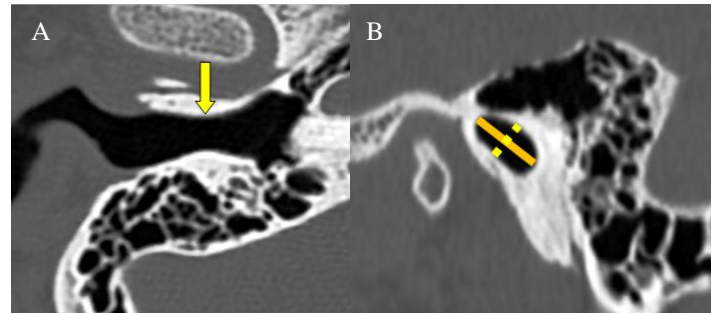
Axial CT image of temporal bone. 2nd measurement point is at the level of isthmus (yellow arrow), 2B: Sagittal CT image of the temporal bone. Diameters at the level of the isthmus (2a: non-interrupted line, 2b: interrupted line)
